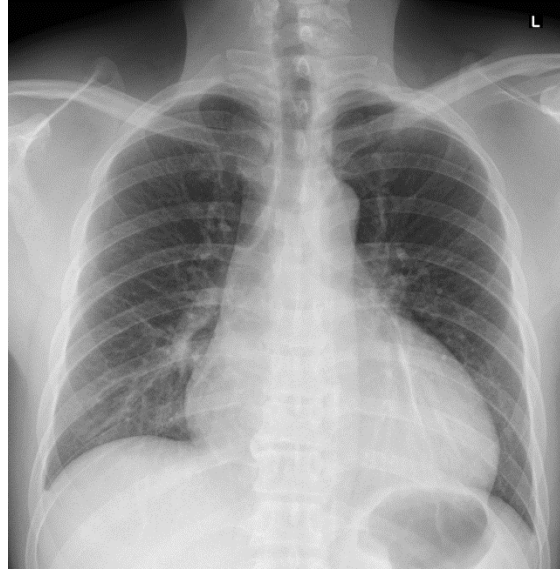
Chest radiograph showed left retrocardiac opacities. Cardiac silhouette appears normal.
